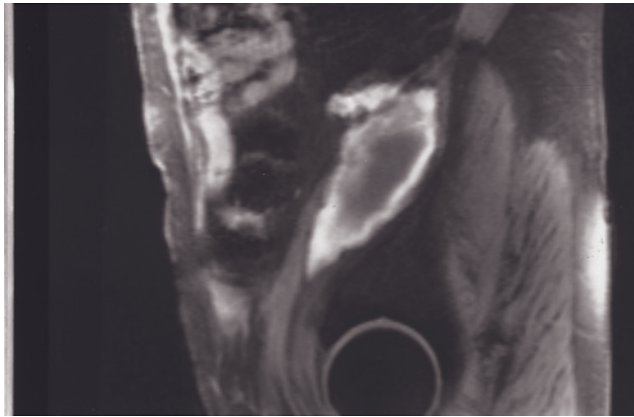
(Continued) postgadolinium interstitial-phase magnetization prepared rapid gradient echo (*j*) images at 3.0 T demonstrate multiple retroperitoneal (black arrows, *i, j*), intraperitoneal, and subcutaneous abscess in another noncooperative patient with similar findings. T2-weighted fat-suppressed single-shot echo-train spin-echo (*k*), T1-weighted SGE (*l*), and T1-weighted postgadolinium interstitial-phase fat-suppressed SGE (*m*) images demonstrate left iliopsoas abscess in another patient. Septations are again present in the abscess cavity. The left psoas muscle shows intense inflammatory enhancement on postgadolinium image. The transversalis fascia (arrows, *m*) also shows intense enhancement. Note that there is inflammation in the left subcutaneous region adjacent to the abscess cavity as well.
